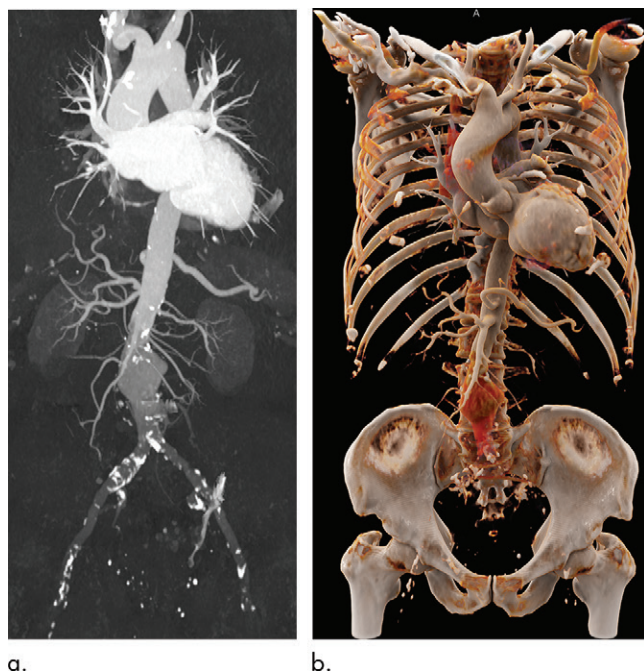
Images in an 84-year-old male study participant with untreated infrarenal aortic aneurysm. (a) Contrast material-enhanced CT angiography with fixed trigger delay in coronal maximum intensity projection after bone removal and (b) cinematic rendering. Gradual reduction of attenuation from cranial to caudal resulted in adjudication of score 5 (nondiagnostic image quality) by both readers.
